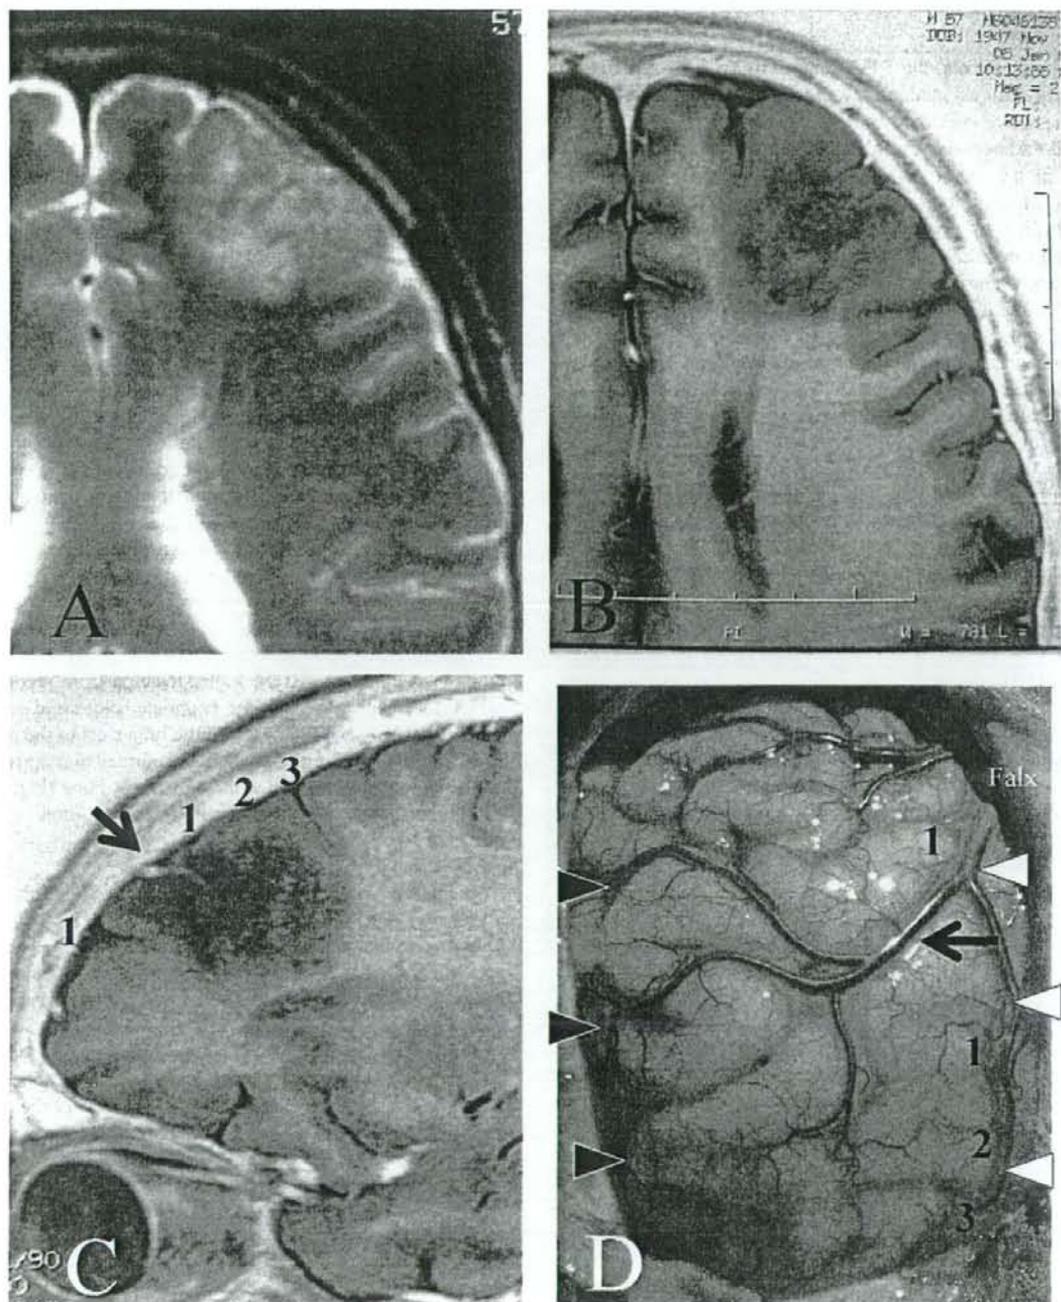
Images for Case 1. The cortical vessels and sulci were visualized more clearly on axial STIR using 3.0T MRI (B) than on T2WI using 1.5T MRI (A). Sagittal STIR (C) demonstrates the tumor bulk located within gyri between the first sulcus forward and the third sulcus back from a cortical vein (arrow). The sulcus number is indicated with a numeral. Cortical surface showing normal colour (D). Surgical findings of a cortical vein (arrow), the superior frontal sulcus (white arrowheads), the inferior frontal sulcus (black arrowheads), and numerals showing the sulcus numbers correspond to those on the sagittal STIR image. Postoperative STIR (E) shows that the tumor has been debulked accurately, although postsurgical edema is seen in the white matter adjacent to the tumor bed.
